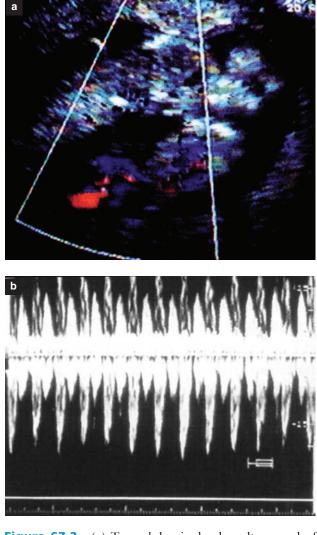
(a) Transabdominal color ultrasound of a monochorionic–monoamniotic twin pregnancy at 14 weeks. Note the cord entanglement of the two cords close to the umbilical insertion. (b) Doppler velocimetry of the same segment showing the flow velocity waveforms of four different arteries with two different heart rates
